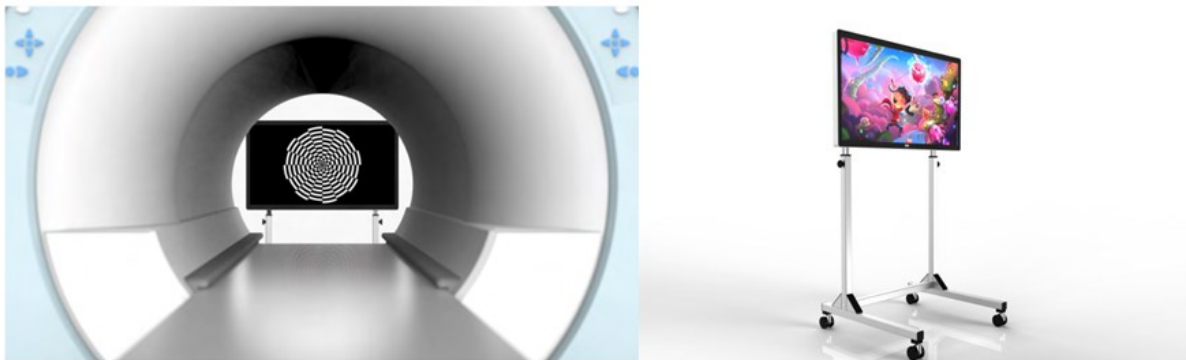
Inroom Viewing device, respectively, show in full, on the right, and placed in front of the MRI scan tube, on the left.
